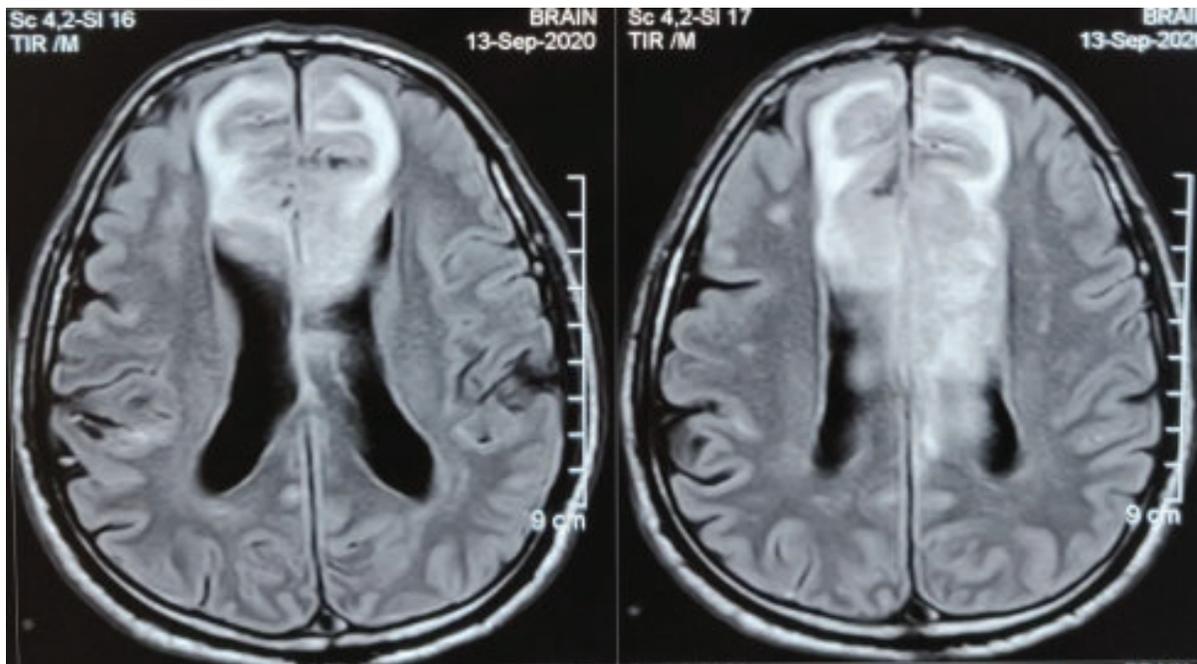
MRI of brain fluid-attenuated inversion recovery (FLAIR) sequence showing bilateral cerebral infarction involving anterior cerebral artery territory
